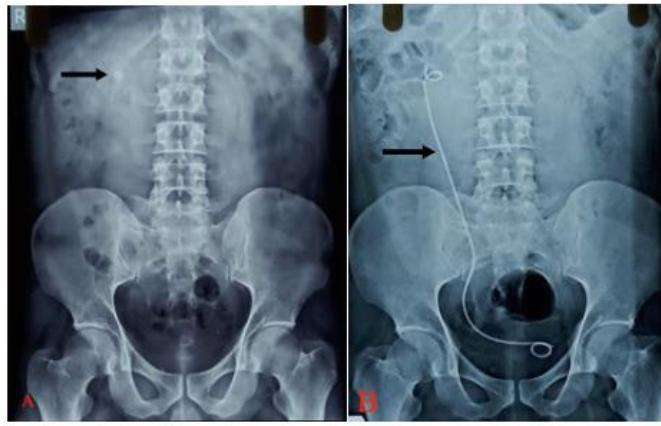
(A) Preoperative X-ray KUB revealed stone shadows (arrow) in the right abdominal area. (B) Postoperative KUB showed no stone shadows and arrow show DJ stent.
